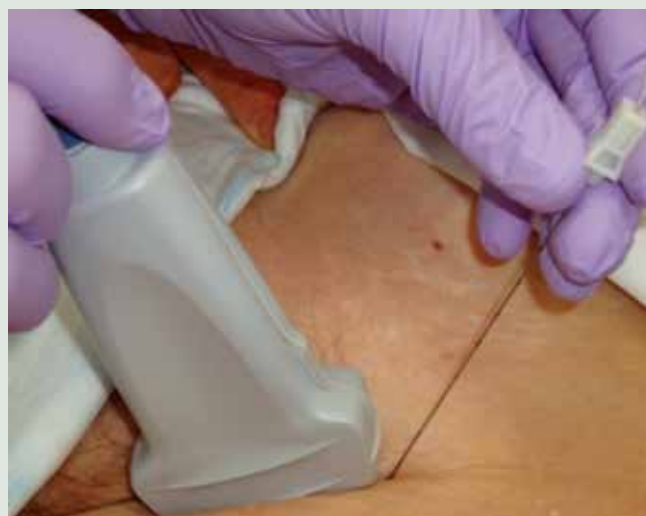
In plane approach for ultrasound guided block of the femoral nerve.
